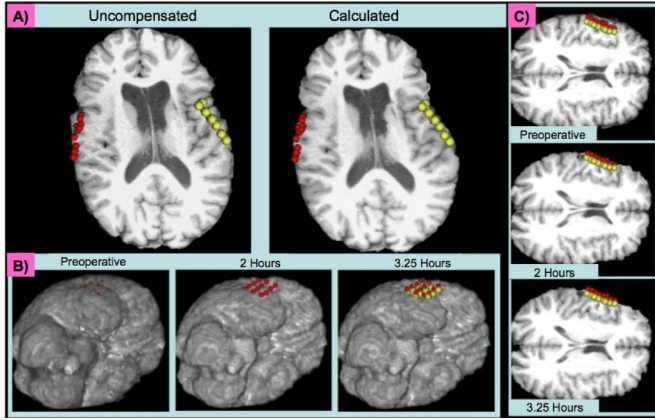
(A) An axial slice of the preoperative MRI (left) which has been deformed using the linear elastic model (right). The red and yellow spheres indicate the surface points acquired during surgery. (B) Volume renderings of the preoperative (left) and predicted (middle and right) MR images. The red spheres were acquired by the neurosurgeon 2 h into surgery and the yellow spheres were acquired 75 min later. (C) One axial slice of the preoperative (top) and predicted (middle and bottom) MR images from (B). As the surface sinks toward the midline over time, the deformation is propagated through the hemisphere and the ventricle begins to collapse. The same red and yellow spheres from (B) are plotted here relative to the single MR image slice.
